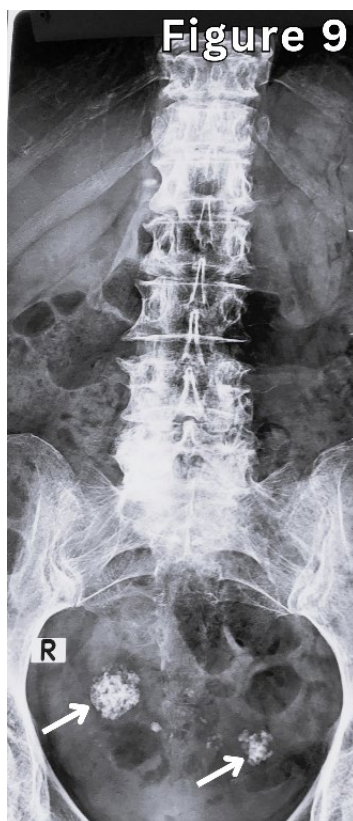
A 51-year-old female with incidentally detected bilateral pelvic calcified densities on abdominal X-ray. Subsequent contrast-enhanced CT of the pelvis confirmed calcified ovarian lesions.
